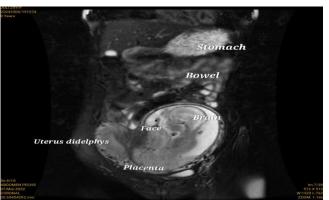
MRI IMAGE OF PREGNANCY IN ONE HORN OF DIDELPHYIC UTERUS A 35 year old patient with infertility was diagnosed with didelphic uterus and complete vaginal septum.
